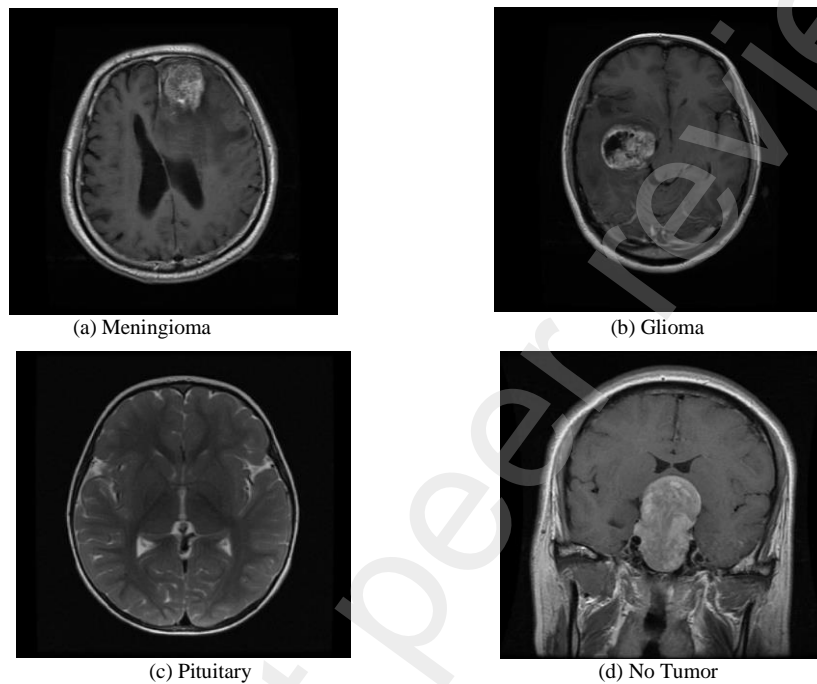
MRI image of BTs (a) Meningioma, (b) Glioma, (c) Pituitary, (d) No Tumor
